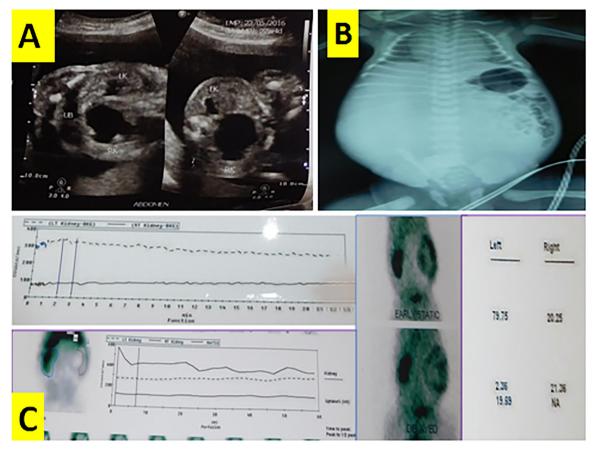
(A) Antenatal ultrasonography – showing features of hydronephrosis. (B) Postnatal erect abdomen X-ray showing. (C) Preopeartive radionucleide EC scan showing features of PUJO.
